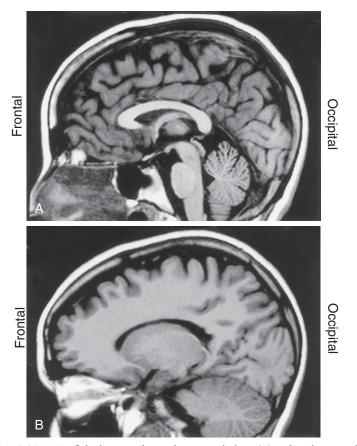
MRI of the brain in the median sagittal plane (A) and in the sagittal plane but off the midline (B). The frontal lobe is to the left, and the occipital lobe is to the right. Other directions within the brain in this plane are appreciated by a comparison with Fig. 1.7.
